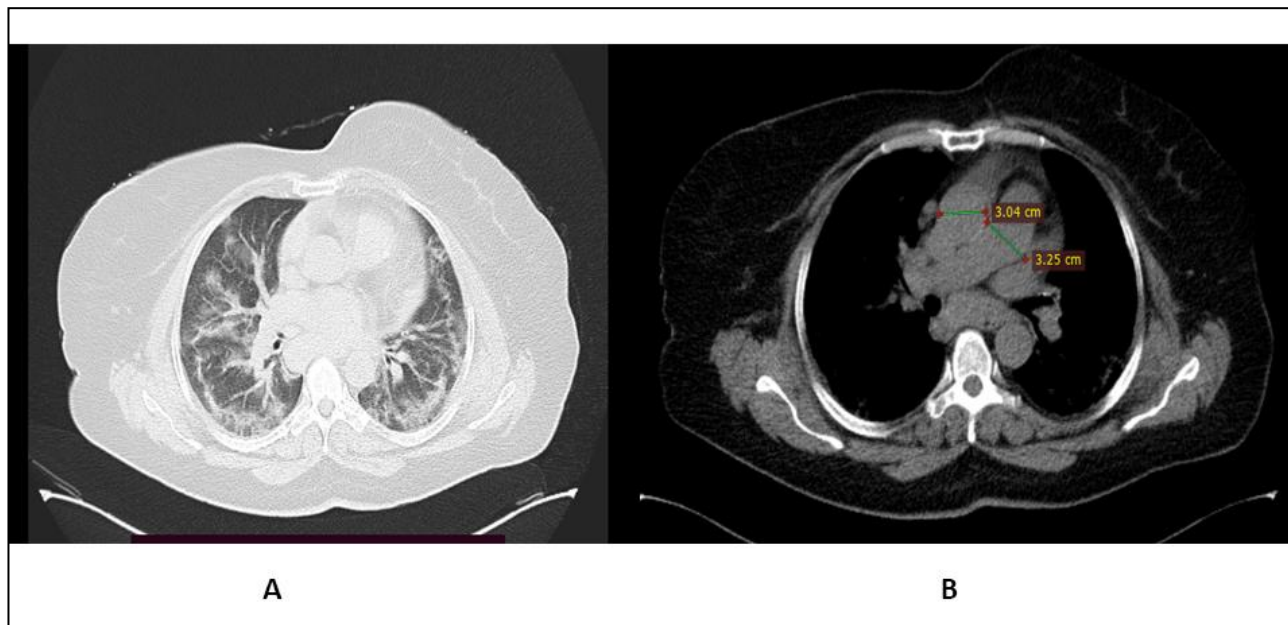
Selected chest axial CT images of a 63-year old female with COVID-19 infection. Lung window image (A) shows diffuse bilateral GGO paranchymal changes with estimated severity score of 18/25 (severe) and the PA/AA ratio assessed on the mediastinal widow image (B) is abnormal (>1).
